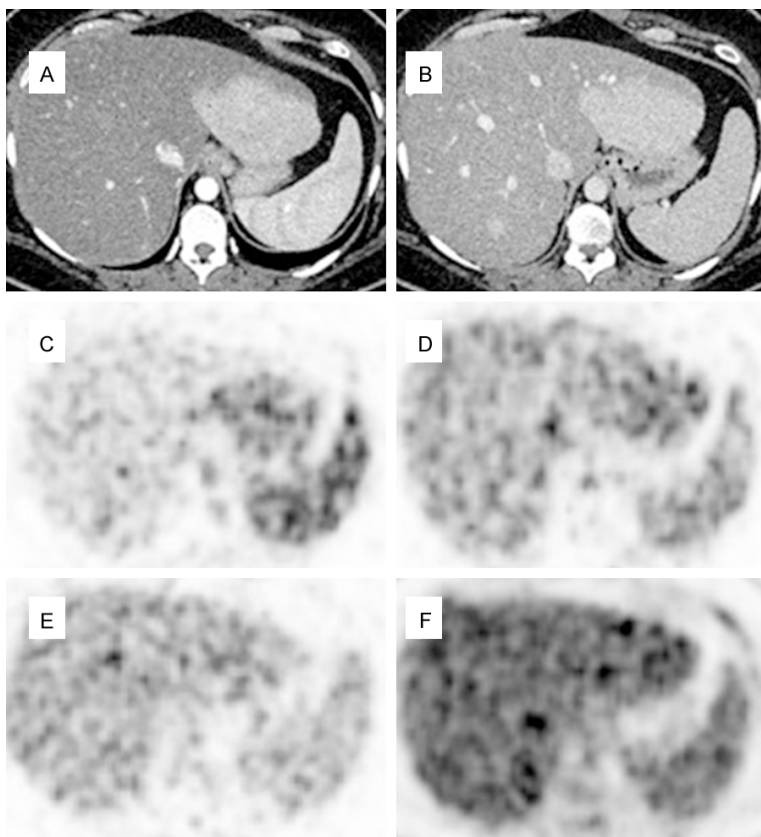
Dynamic FDG PET/CT images in a case with FNH (selected trans-axial frames of the liver). Arterial (A) and venous phase (B) CT shows an enhancing mass in the left hepatic lobe. PET in arterial phase shows hyper-perfusion in the mass (C). PET in venous phase (D) shows some washout, and PET in late venous phase (E) shows further washout of activity in the mass with only mild activity. Delayed PET at 90 min (F) shows isometabolic activity in the region of the mass as compared to normal liver.
